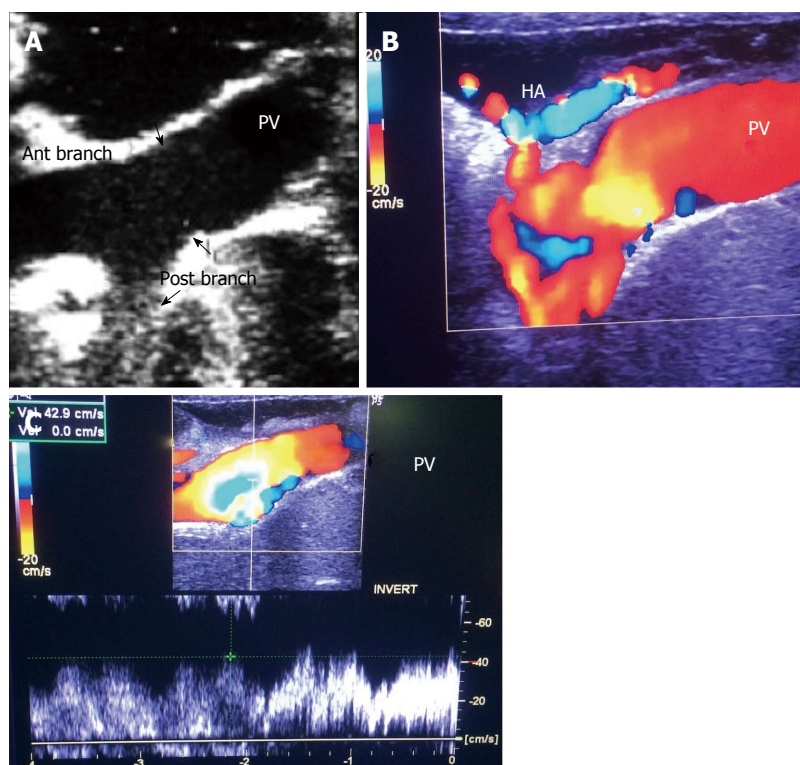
Intra-operative ultrasound evaluation of portal vein anastomosis. A: B-mode ultrasound image showing the extrahepatic portal vein and intrahepatic bifurcation. The suture line appears as echogenic shadows at the site of anastomosis (arrows); B: Color image showing homogeneous color saturation in the PV with mild aliasing at site of anastomosis and at the PV bifurcation; C: Color Doppler image showing antegrade normal pulsatile flow in the PV. PV: Portal vein; HA: Hepatic artery.
